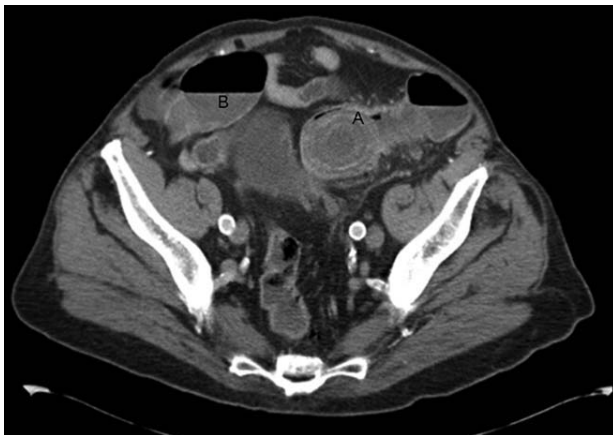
CT abdomen demonstrating impacted sigmoid gallstone.
